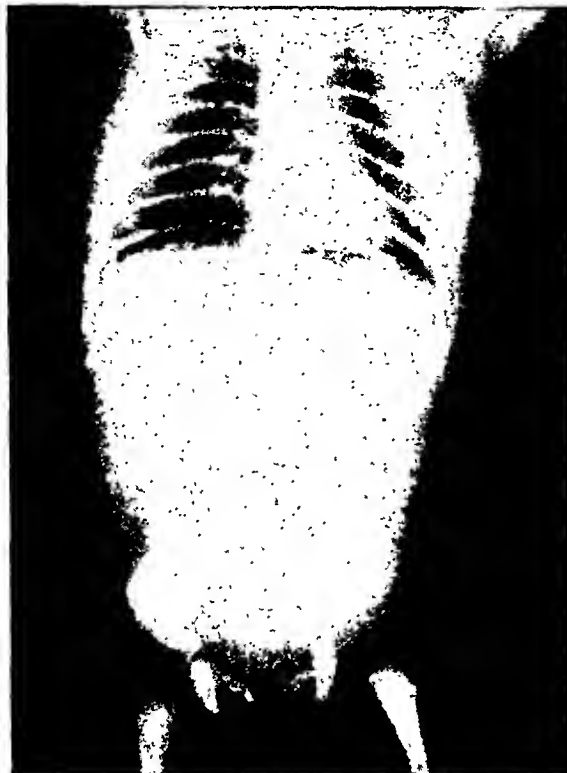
Case 1: Roentgenogram of Baby S. T. A. before relief of the obstruction.
